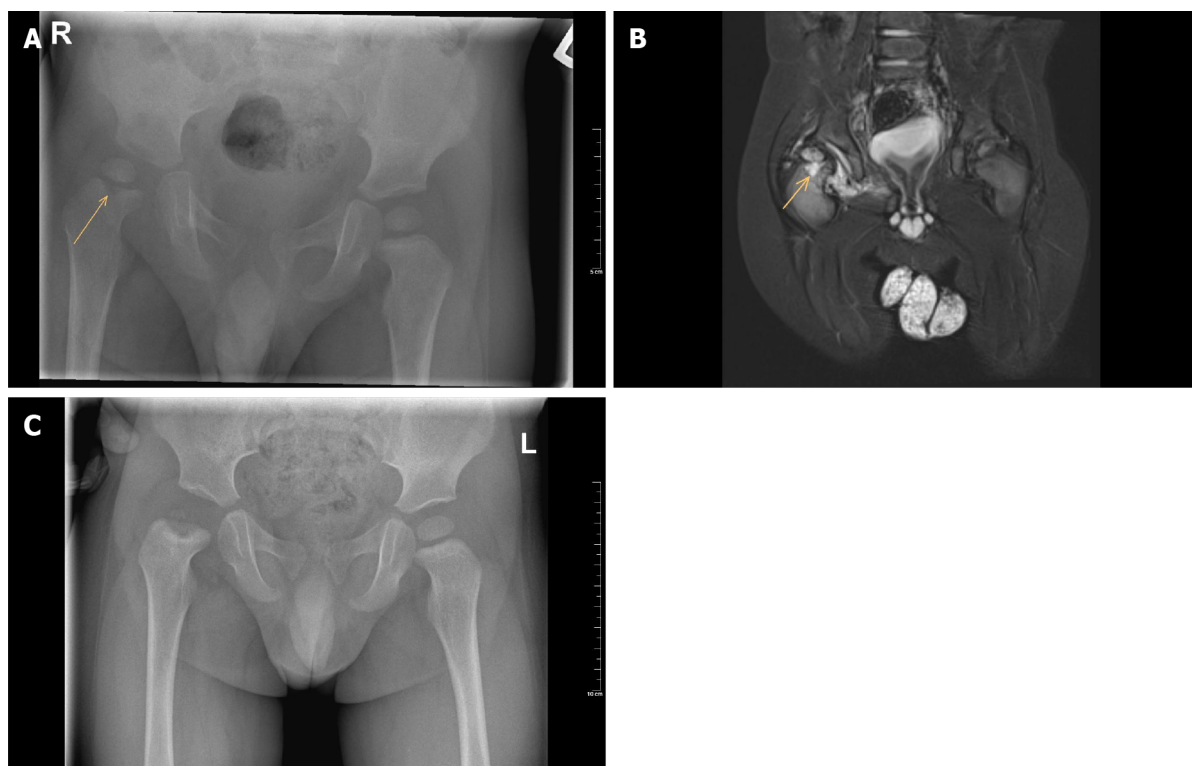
Radiograph images. A: Plain anteroposterior pelvic radiograph of a one-year-old boy with septic hip arthritis showing concomitant osteomyelitis of the proximal femur at the right side (arrow); B: T2 magnetic resonance imaging coronal view confirms joint effusion, suggestive of hip arthritis, and increased signal of the metaphysis, suggestive of osteomyelitis (arrow); C: Plain anteroposterior radiograph of the same boy after six months follow-up, which shows avascular necrosis of the femoral head.
